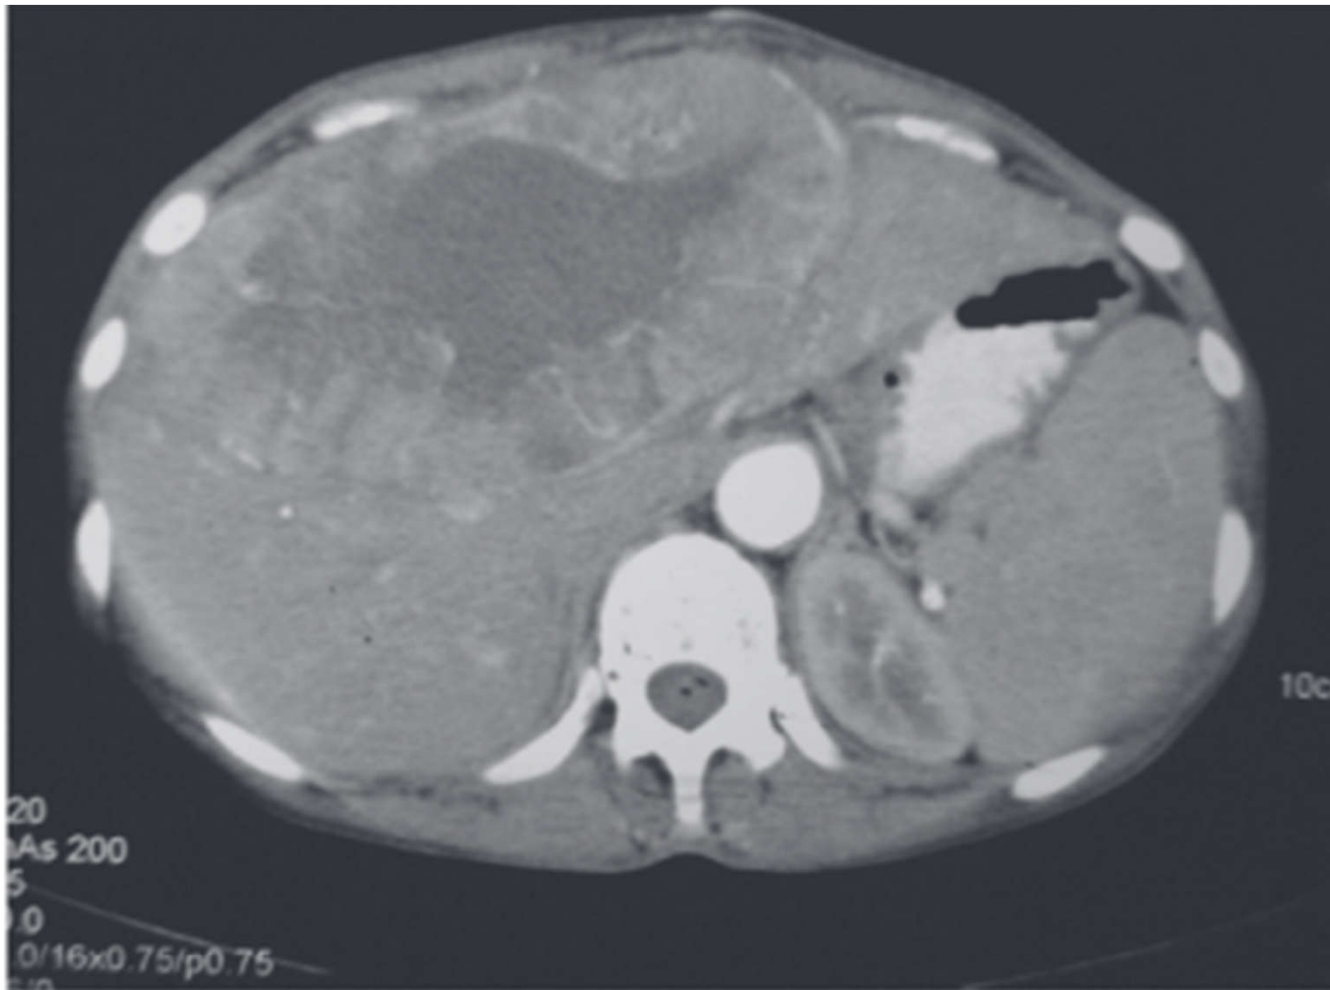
Contrast enhanced computed tomography (CECT) abdomen revealed 13.2 x 13.5 x 7.3 cm well defined mass lesion involving segment IV, V and VIII of liver. There was rim enhancement on arterial phase and no contrast retention on venous phase.
